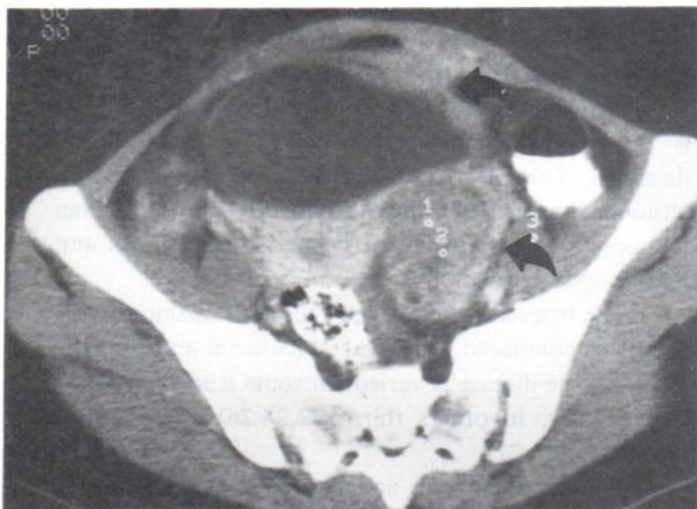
Left ovarian lesion, at CT scan
